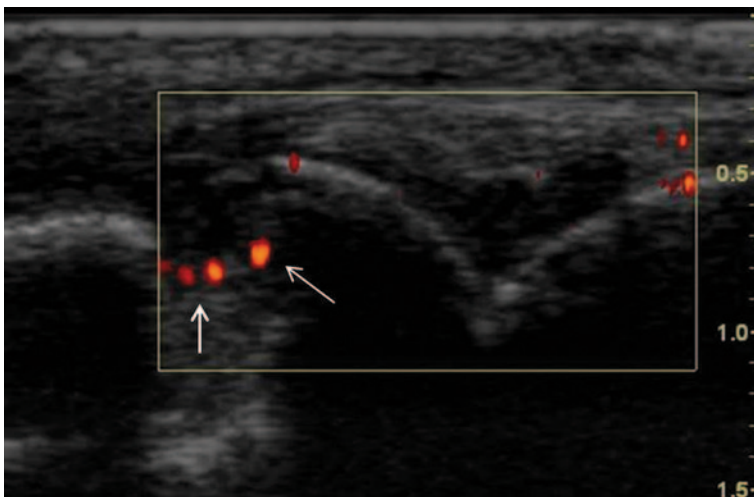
Ultrasound image of bone erosion in psoriatic arthritis filled with inflammatory tissue exhibiting vascularity in Doppler mode (*white arrows*)
